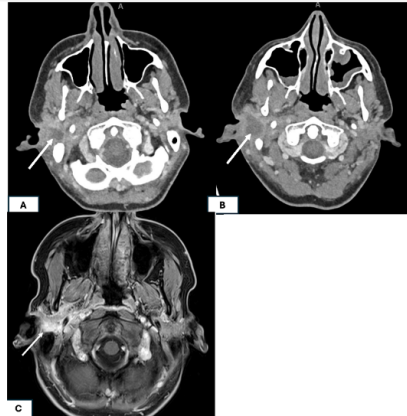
(A) CT scan on initial presentation demonstrating 2.4 x 2.1 cm hypoattenuating lesion in the right superior parotid space (white arrow). (B) CT scan 3 months later demonstrating a 3.4 cm parotid abscess in the same location (white arrow). (C) MRI demonstrating right-sided persistent enhancement along the stylomastoid foramen, infratemporal fossa, and the mastoid process (white arrow).
